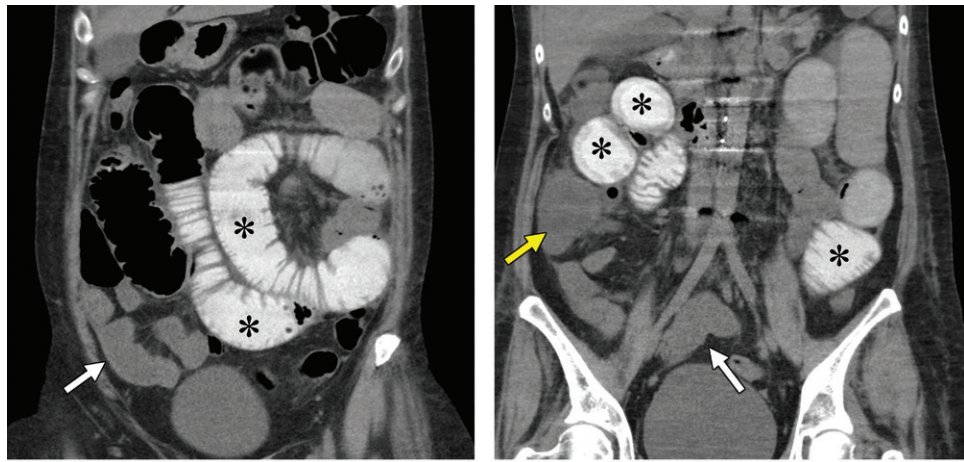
Metastatic clear cell RCC with enteritis in a 55-year-old woman who underwent checkpoint inhibition therapy. The patient developed abdominal pain and high-grade diarrhea after completion of a second cycle of combination therapy with ipilimumab and nivolumab. Coronal reconstructions of a non-enhanced CT examination reveal dilatation of proximal small bowel loops filled with oral contrast material (*), with fluid-filled nondistended loops of the distal small bowel (white arrow). Note the fluid-filled cecum (yellow arrow in b) in the right lower quadrant. Small-bowel biopsy results confirmed findings consistent with immunomodulatory enteritis.
